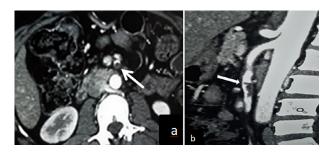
Axial (A) and sagittal (B) CT sections showing significant stenosis of the superior mesenteric artery (arrows)
